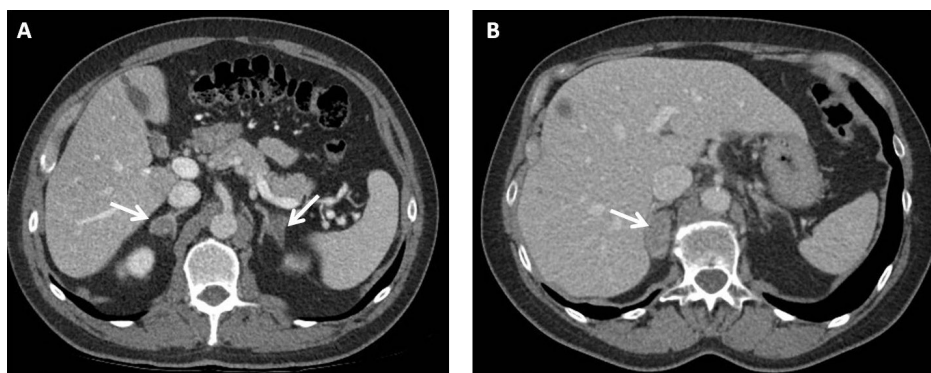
A. Adrenal CT-scan with bilateral hyperplasia. B. Adrenal CT-scan with an adenoma of the right adrenal gland
